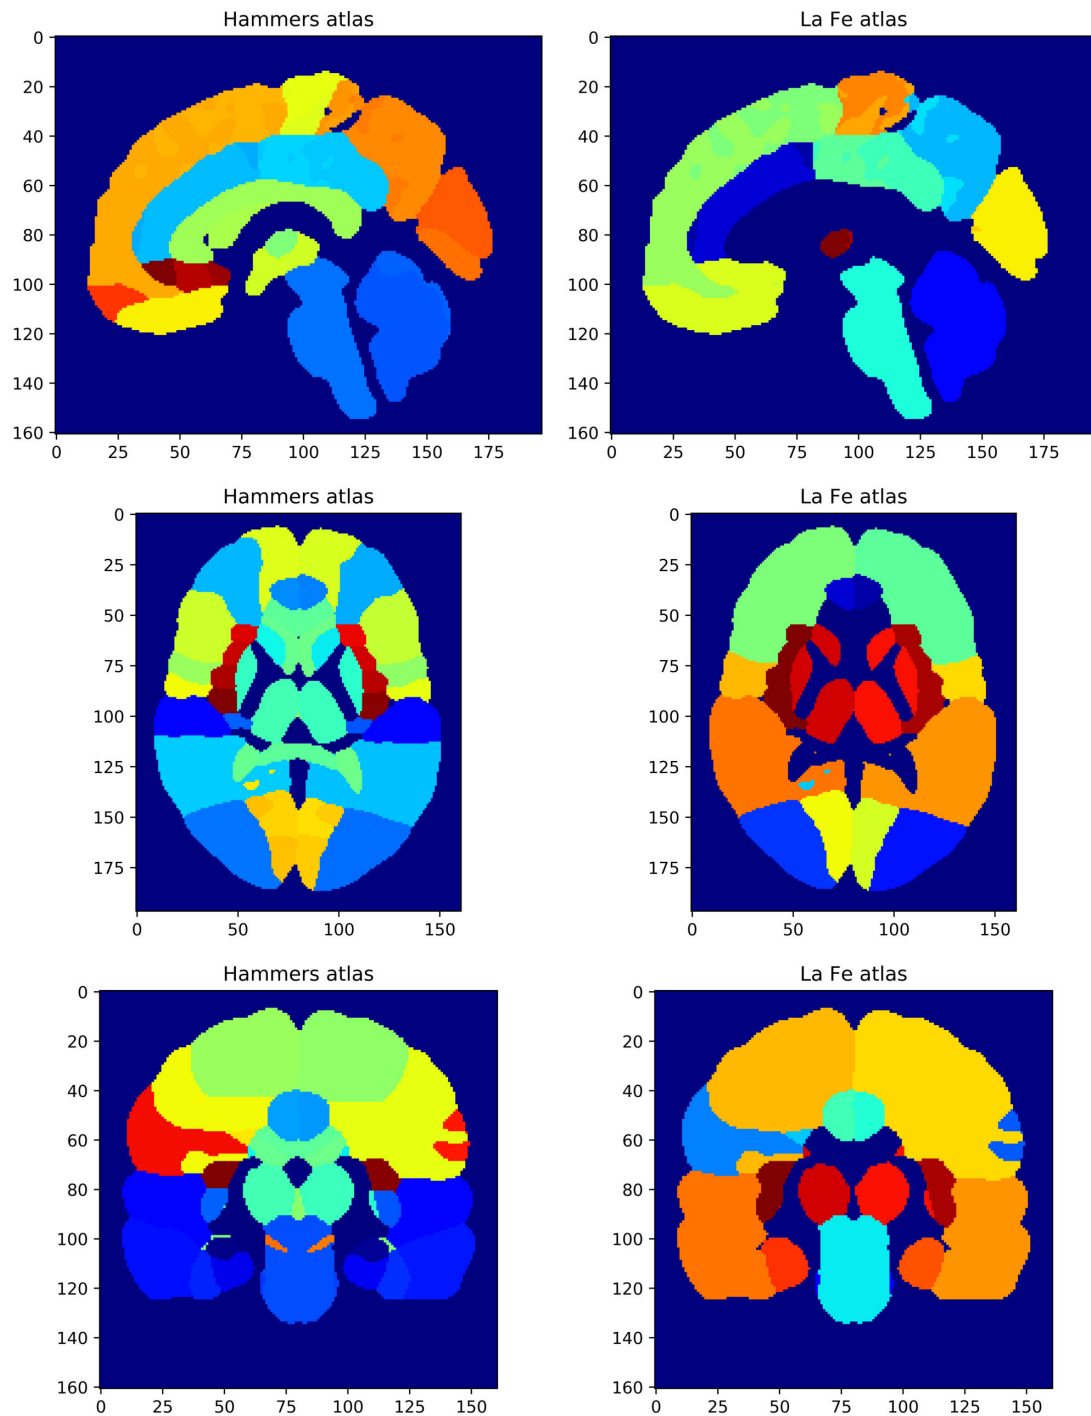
Modification of the Hammers VOI atlas (left) to La Fe atlas (right). From “Objective image quality comparison between brain-dedicated PET and PET/CT scanners.” by Maria Teresa Gandia-Ferrero, Irene Torres-Espallardo et al. 2023. Copyright by Journal of Medical Systems.
